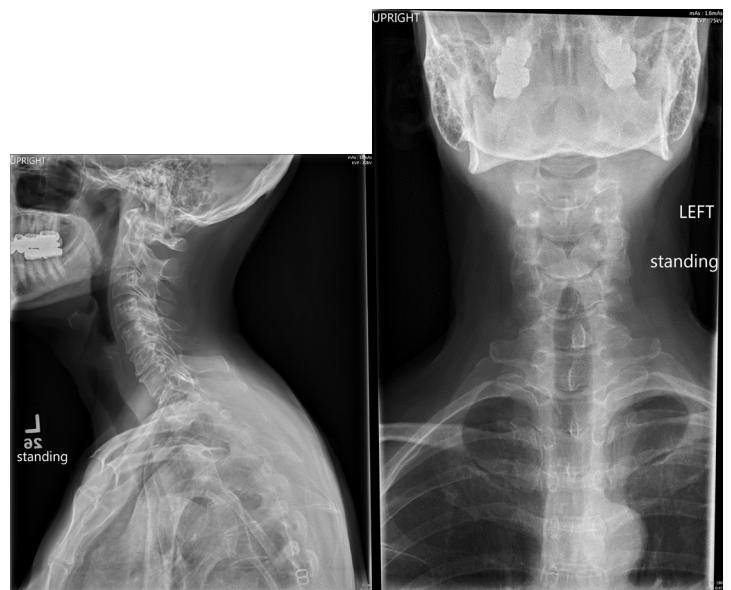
Lateral cervical spine X-ray and image 4 antero-posterior X-ray of the cervical spine reveals degenerative cervical spondylosis with multilevel degenerative disc disease and multilevel facet arthropathy.
